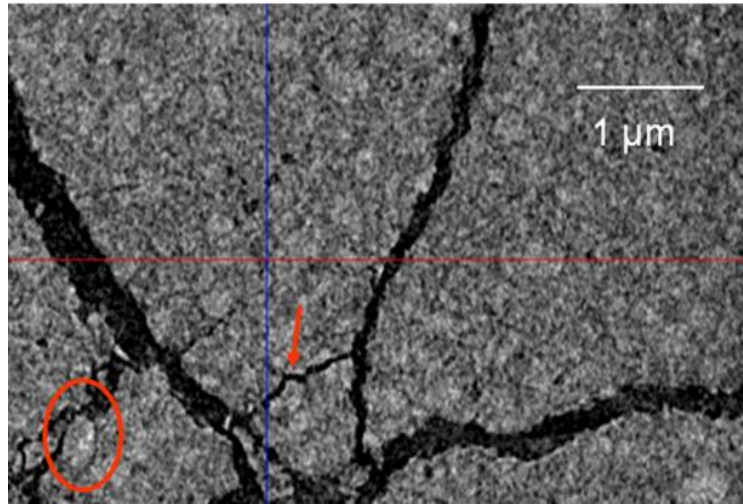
Nano CT image showing that microcracks propagating along the interface of the matrix and glass cores (arrow and oval) [275].
